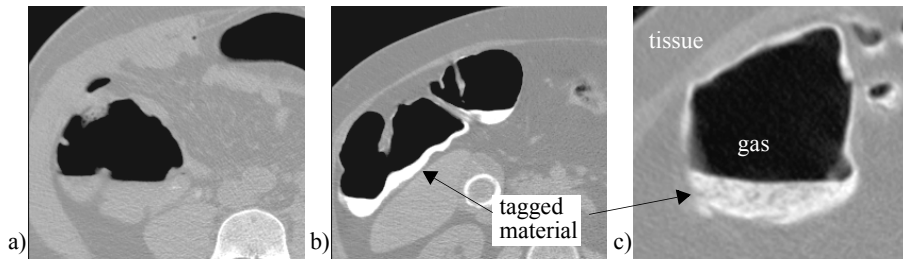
CT data without opacifying contrast (a), with tagged material (b, c)
